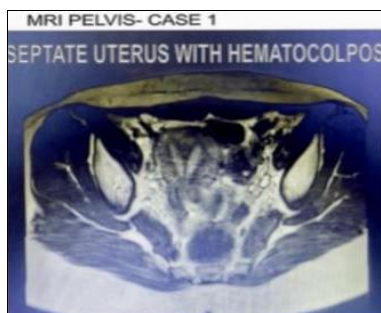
MRI showing septate uterus
